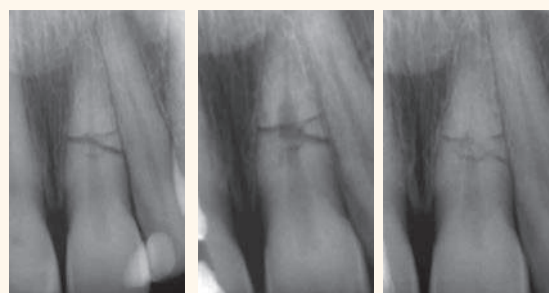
A periapical radiograph of a root fracture a few hours after the injury. It was established that both fragments were in good approximation of each other. Splinting was done for two weeks.
